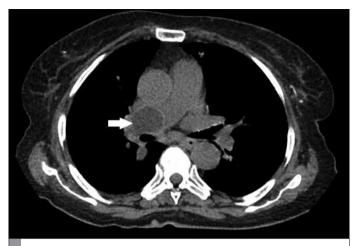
Axial non-contrast-enhanced CT image through the pulmonary artery bifurcation shows a round, well-defined cystic mass in the right pulmonary artery (arrow). The main pulmonary artery diameter is within normal limits.
